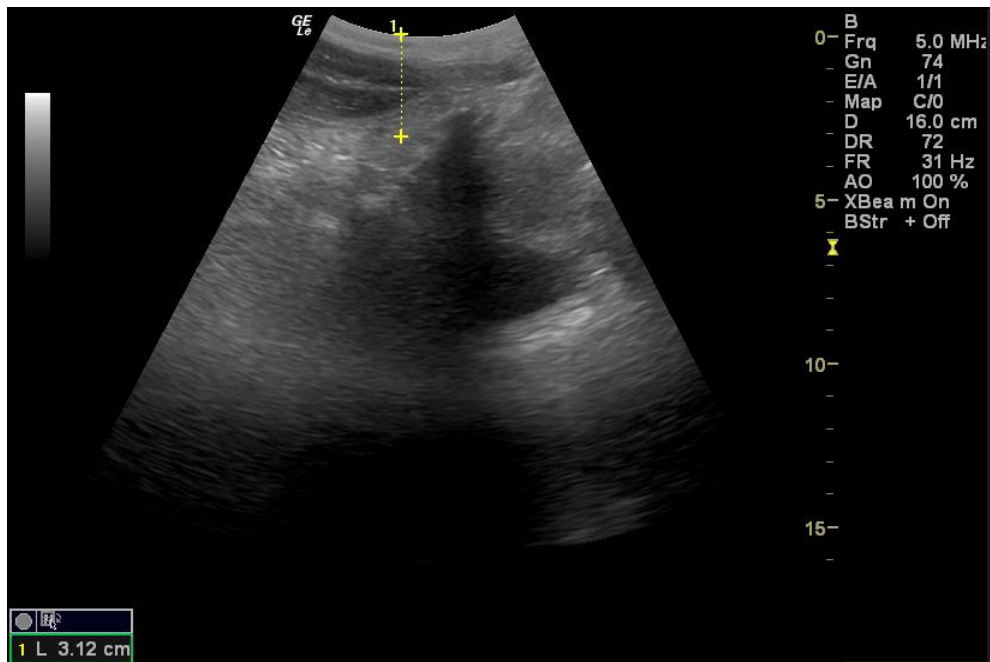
Perineal sonography conducted to determine the distance between the skin surface and the centre of the target organ (prostate)
